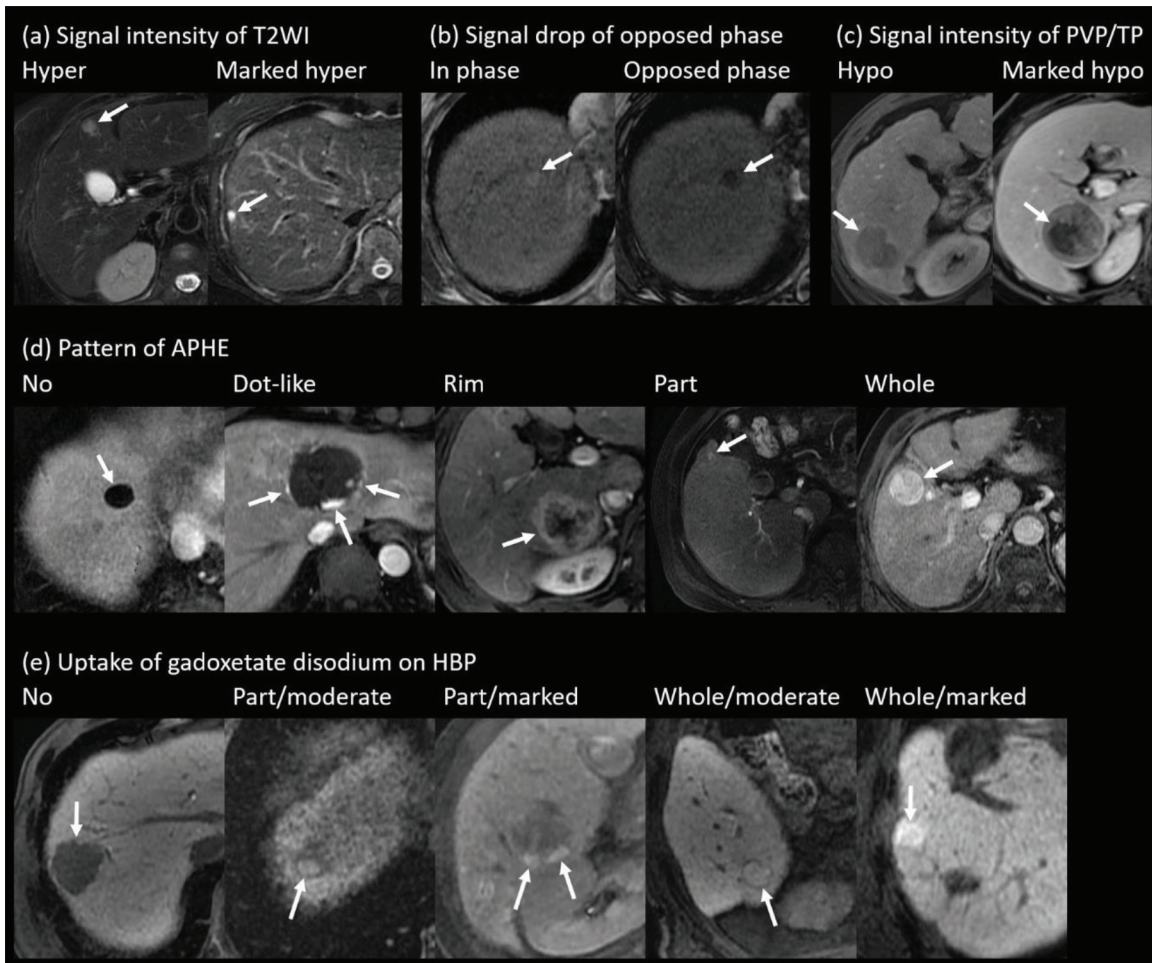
Examples of magnetic resonance images with visual assessment (only item-specific annotation was needed). (a) Signal intensity of T₂-weighted images (T₂WI), (b) signal drop of opposed phase, (c) signal intensity of the portal venous phase (PVP) or transitional phase (TP), (d) pattern of arterial phase hyperenhancement (APHE), and (e) uptake of gadoxetate disodium at the hepatobiliary phase (HBP). All images were obtained in the axial plane. (a) On T₂WI, hyperintensity was higher than that of the surrounding liver but lower than that of water (arrow), while marked hyperintensity was similar to that of water (arrow). (b) Signal drop of opposed phase was defined as a signal of opposed phase lower than in phase signal (arrow). (c) On PVP or TP, hypointensity was lower than that of the surrounding liver but higher than that of water (arrow), while marked hypointensity was similar to that of water (arrow). (d) Pattern of APHE was divided into five categories: no APHE, whole hypointensity on the arterial phase (arrow); dot-like APHE, peripheral slightly marked nodular enhancement (arrows); rim APHE, peripheral layer enhancement (arrow); part APHE, partially higher intensity than in the surrounding liver (arrow); whole APHE, overall higher intensity than in the surrounding liver (arrow). (e) On HBP, pattern of gadoxetate disodium uptake was divided into five categories: no uptake, overall hypointensity (arrow); part and moderate uptake, partially moderate hyperintensity (similar intensity compared with that of the surrounding liver) (arrow); part and marked uptake, partially marked hyperintensity (higher intensity compared with surrounding liver) (arrows); whole and moderate uptake, overall moderate hyperintensity (arrow); whole and marked uptake, overall marked hyperintensity (arrow).
